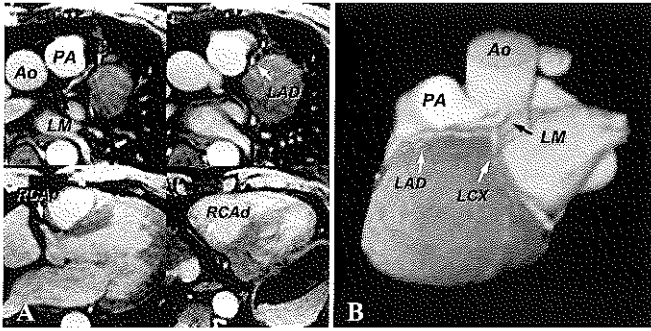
Example of high quality MRI study. (A) Individual slices at different levels showing the left main coronary artery (LM), left anterior descending (LAD), proximal right coronary artery (RCAd), and distal right coronary artery (RCAd). (B) Three-dimensional interpretation of the whole volume using volume rendering software. Ao = Aorta, PA = pulmonary artery.
